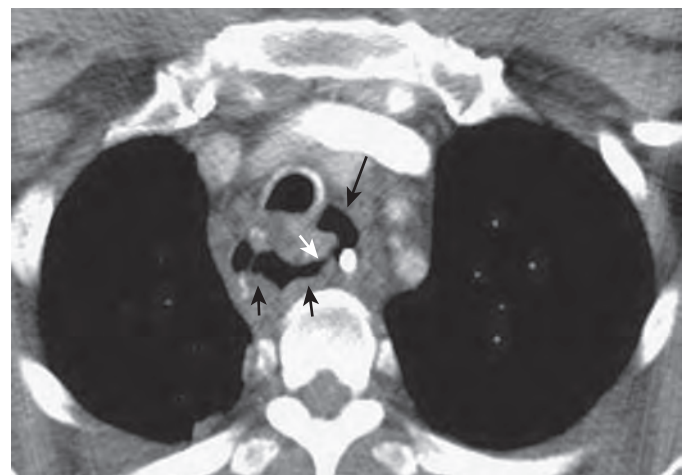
Postsurgical leak into mediastinum on CT. Axial contrast-enhanced CT scan 10 days after an esophagogastrectomy and gastric pull-through shows gas in the proximal end of the intrathoracic stomach (short black arrows) with a focal leak from the anastomotic region (white arrow) into the adjacent mediastinum (long black arrow). (From Lantos JE, Levine MS, Rubesin SE, et al: Comparison between esophagography and chest computed tomography for evaluation of leaks after esophagectomy and gastric pull-through. *J Thorac Imaging* 28:121–128, 2013.)
